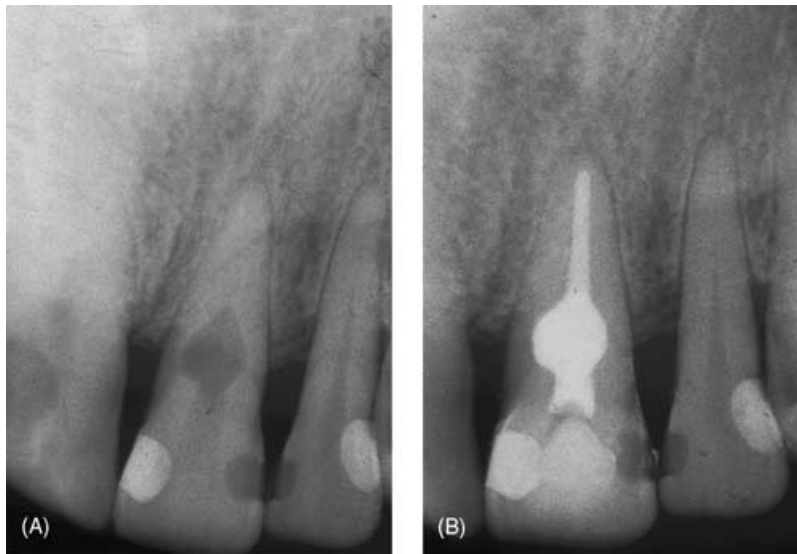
(A) Radiograph showing an internal inflammatory resorptive defect in the coronal third of the root canal of a maxillary central incisor. The tooth tested positive to pulp sensitivity tests. (B) Postoperative radiograph showing obturation of root canal and resorptive defect.
